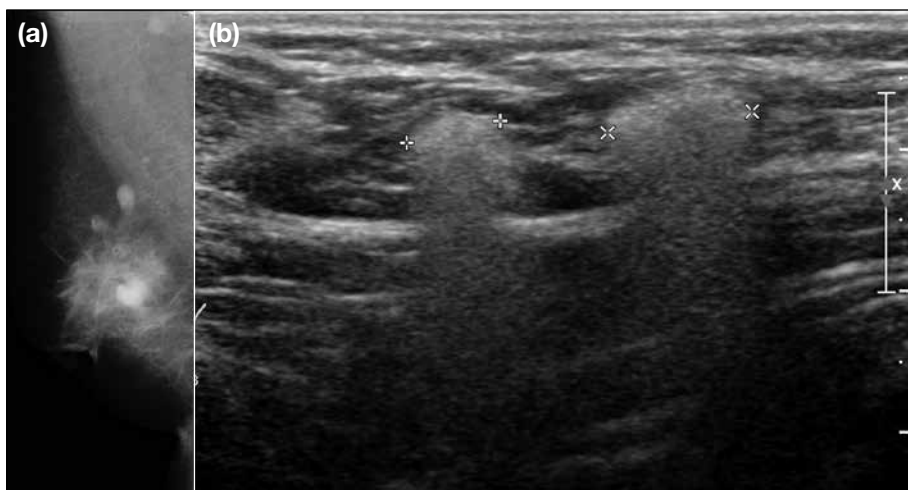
(a) Right mediolateral oblique mammogram of a 51-year-old woman with a history of free silicone injection presenting with breast lumpiness showing multiple dense oval masses. (b) Multiple corresponding echogenic lesions with shadowing, compatible with snowstorm sign are seen on sonography.
